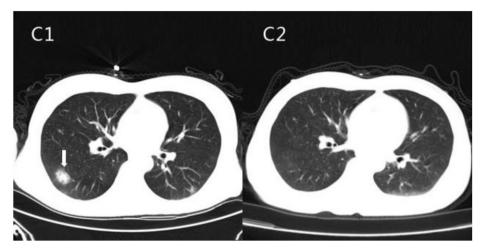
Computed tomography of the male patient's lungs before and after treatment. The arrow indicates a high-density lesion that suggests inflammatory foci before treatment (C1). It disappeared after treatment (C2).
